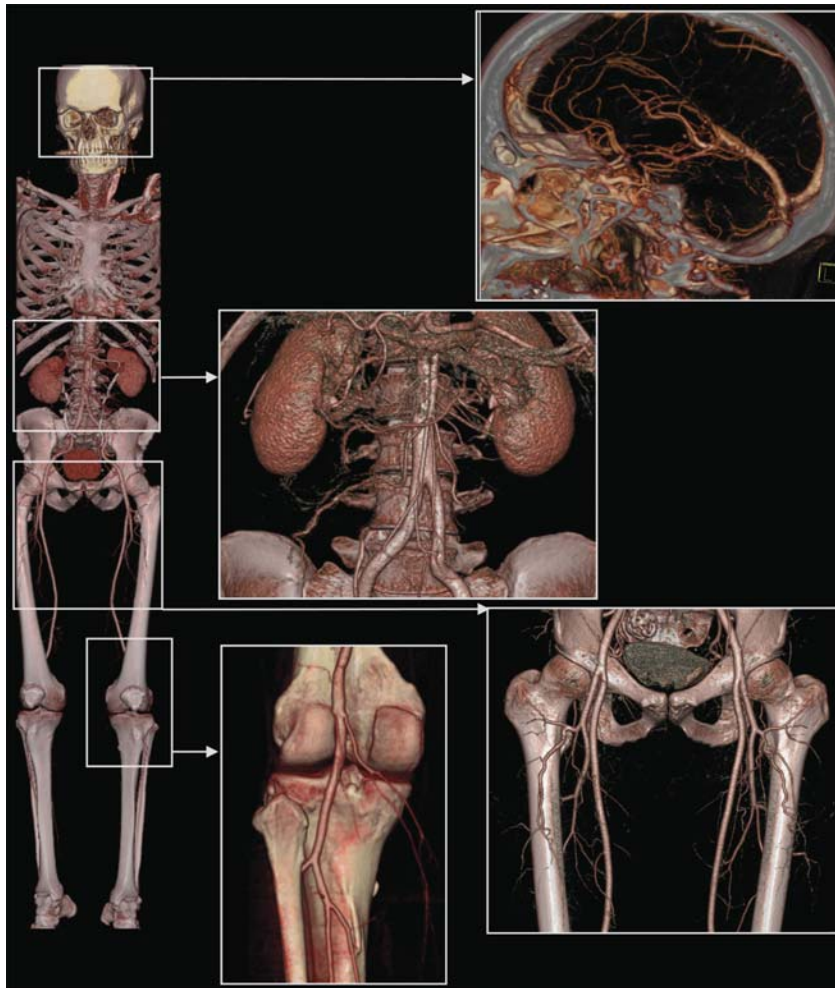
Example of a whole-body CT angiography examination using a 64-slice CT with z-flying focal spot. Blow-up displays of the individual anatomical regions demonstrate the uncompromised regional resolution. Scan parameters: 120 kV, 150 effective mAs, 0.6 mm collimation, 0.375-s gantry rotation time, pitch 1.4, scan time 24 s for 1570-mm scan range. (Case courtesy of the University of Erlangen and the University of Tübingen, Germany)
